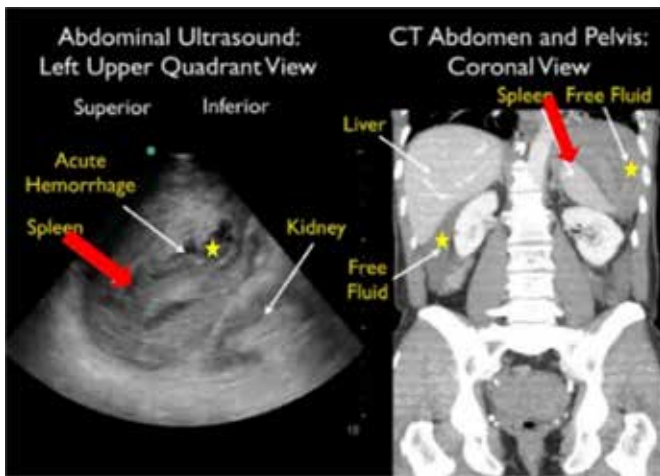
Ultrasound image (left) and computed tomography (right) showing splenic trauma in a 64-year-old man who presented to the emergency room, developed hypovolemic shock, and was treated surgically<sup>11</sup>.
